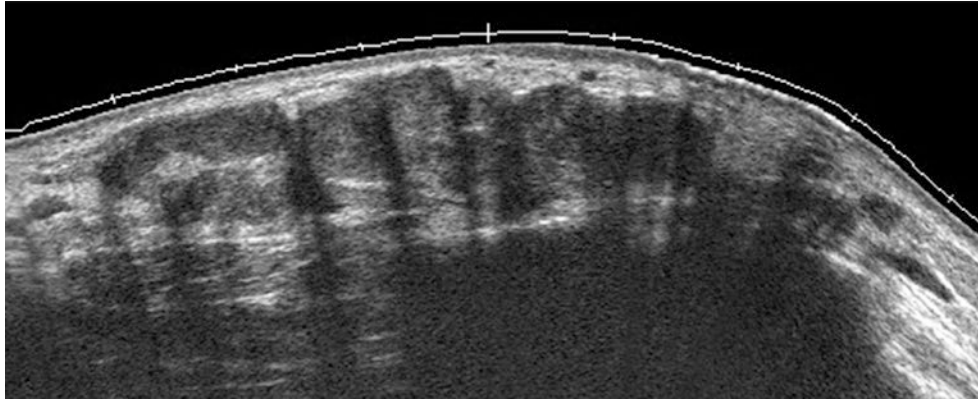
Hyalohyphomycosis. Ultrasound (greyscale, transverse view; dorsum of the right wrist) shows conglomerate of hypoechoic hypodermal nodules.
